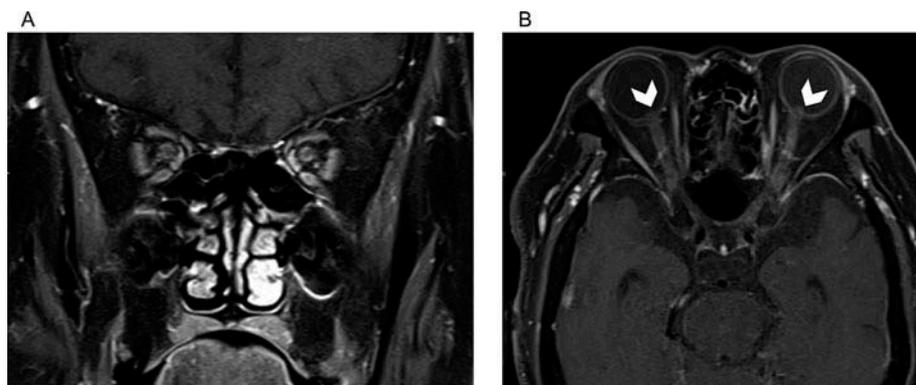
Gadolinium-enhanced T1-weighted coronal (A) and axial (B) magnetic resonance images. Enhancement of the bilateral optic nerve sheaths is evident in (A) and (B). Protrusion of the optic disc into the vitreous cavity (arrowheads) is also observed in (B).
